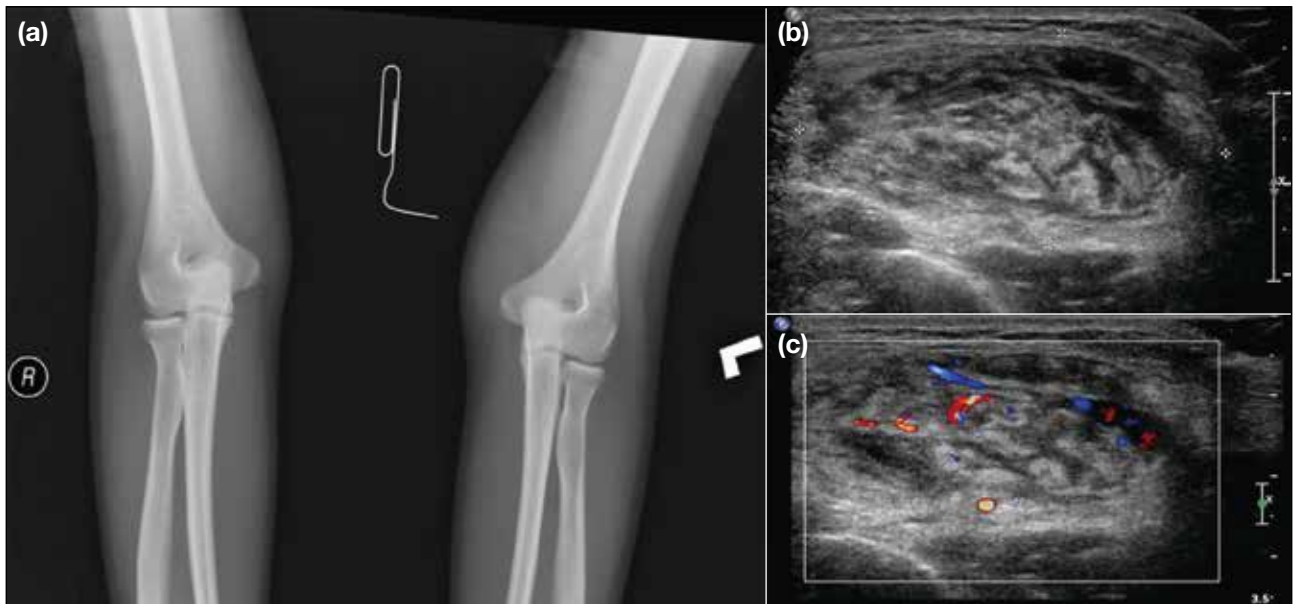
(a) Frontal radiograph of both elbows in case 1 showing subcutaneous soft tissue swellings without calcification or bone changes. (b) Ultrasound of left elbow in case 1 showed poorly defined heterogeneous hypoechoic lesion with internal hyperechoic bands. (c) In the ultrasound image of left elbow in case 1, the mass showed moderate vascularity on colour Doppler.
